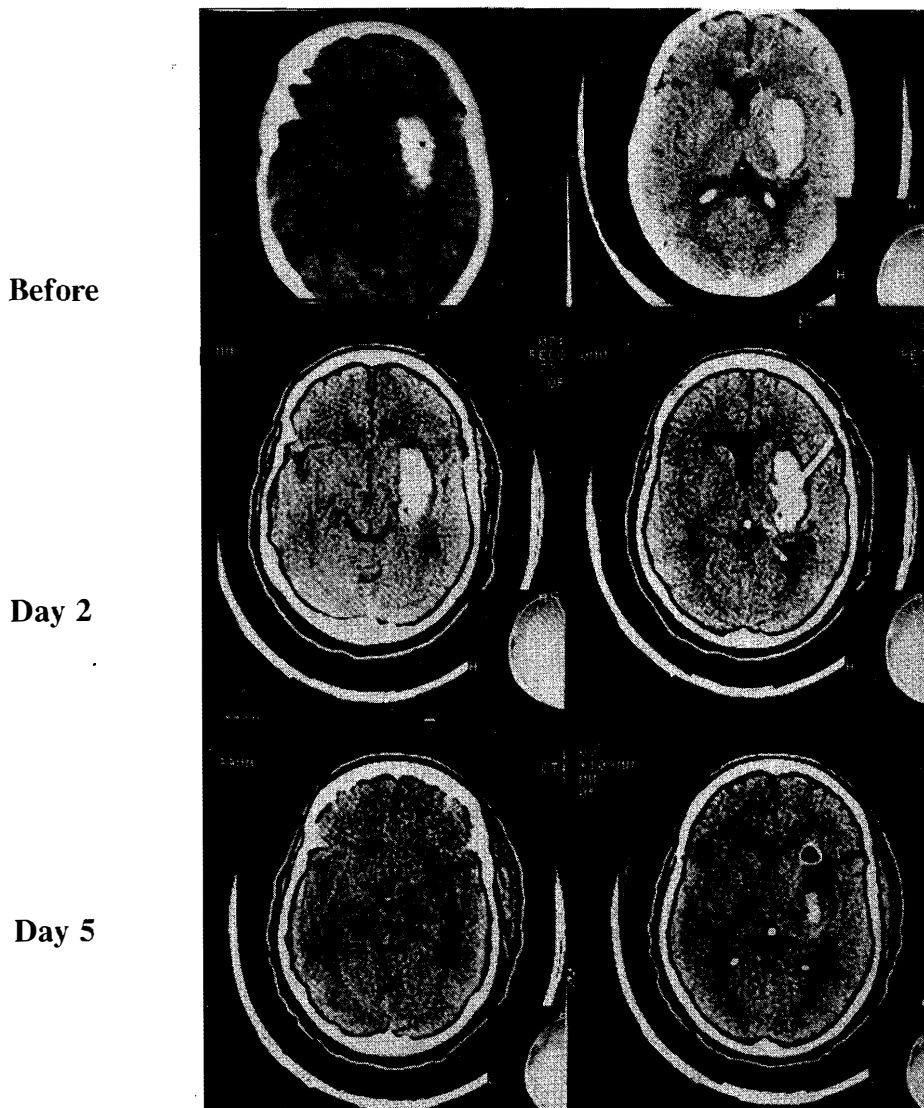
CT findings in case 16 before and after urokinase infusion therapy.
